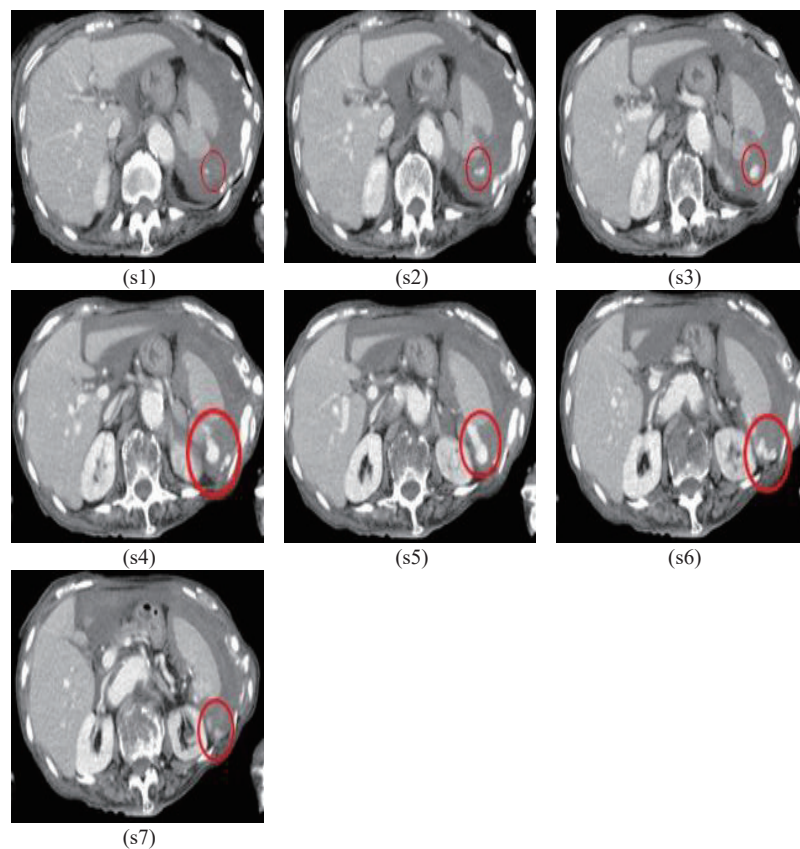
Sequential CT showing extravasation (marked with circles) within the spleen, where s_1, \dots, s_7 indicate slice #1, \dots , slice #7.
